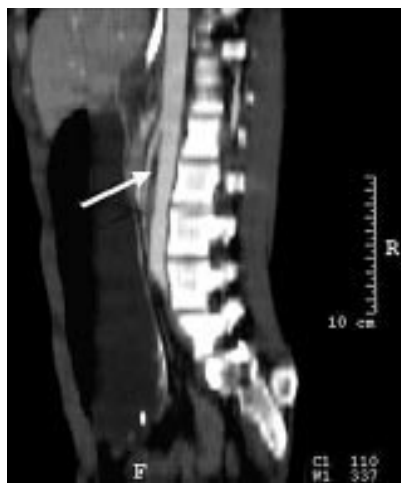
Multislice CT with intravenous contrast medium: sagittal reconstruction through mid-abdomen. The angle between the superior mesenteric artery and the aorta is reduced causing compression of the duodenum (arrow). Note grossly dilated stomach anteriorly.
